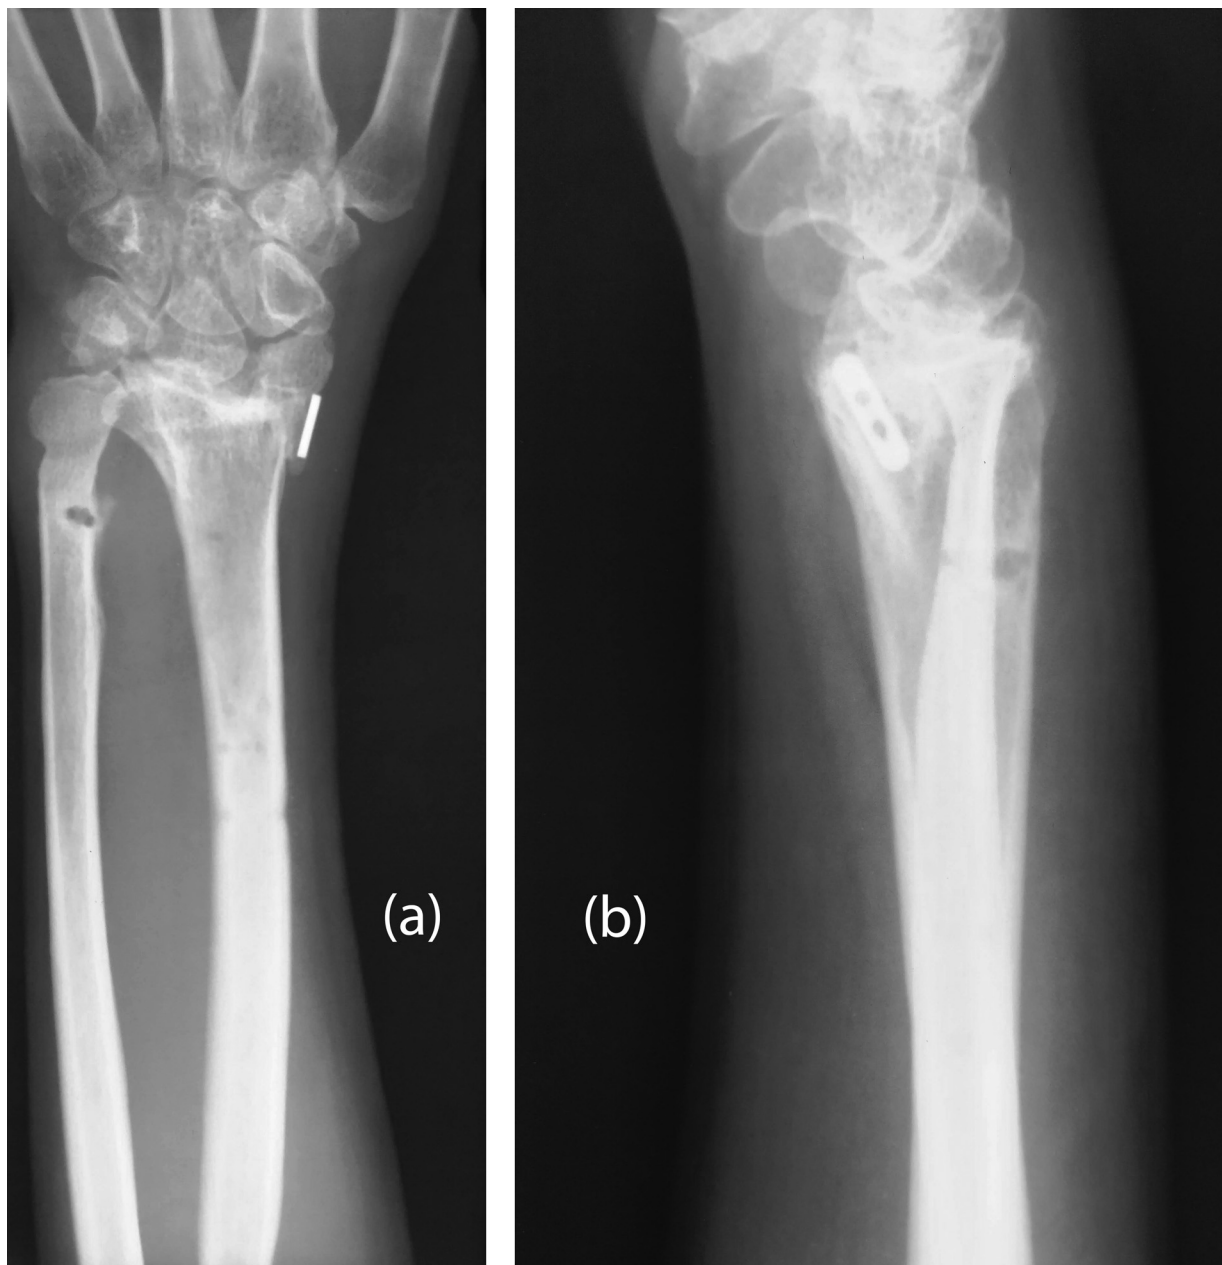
Postoperative X-ray of the Wrist (PA and lateral views).
